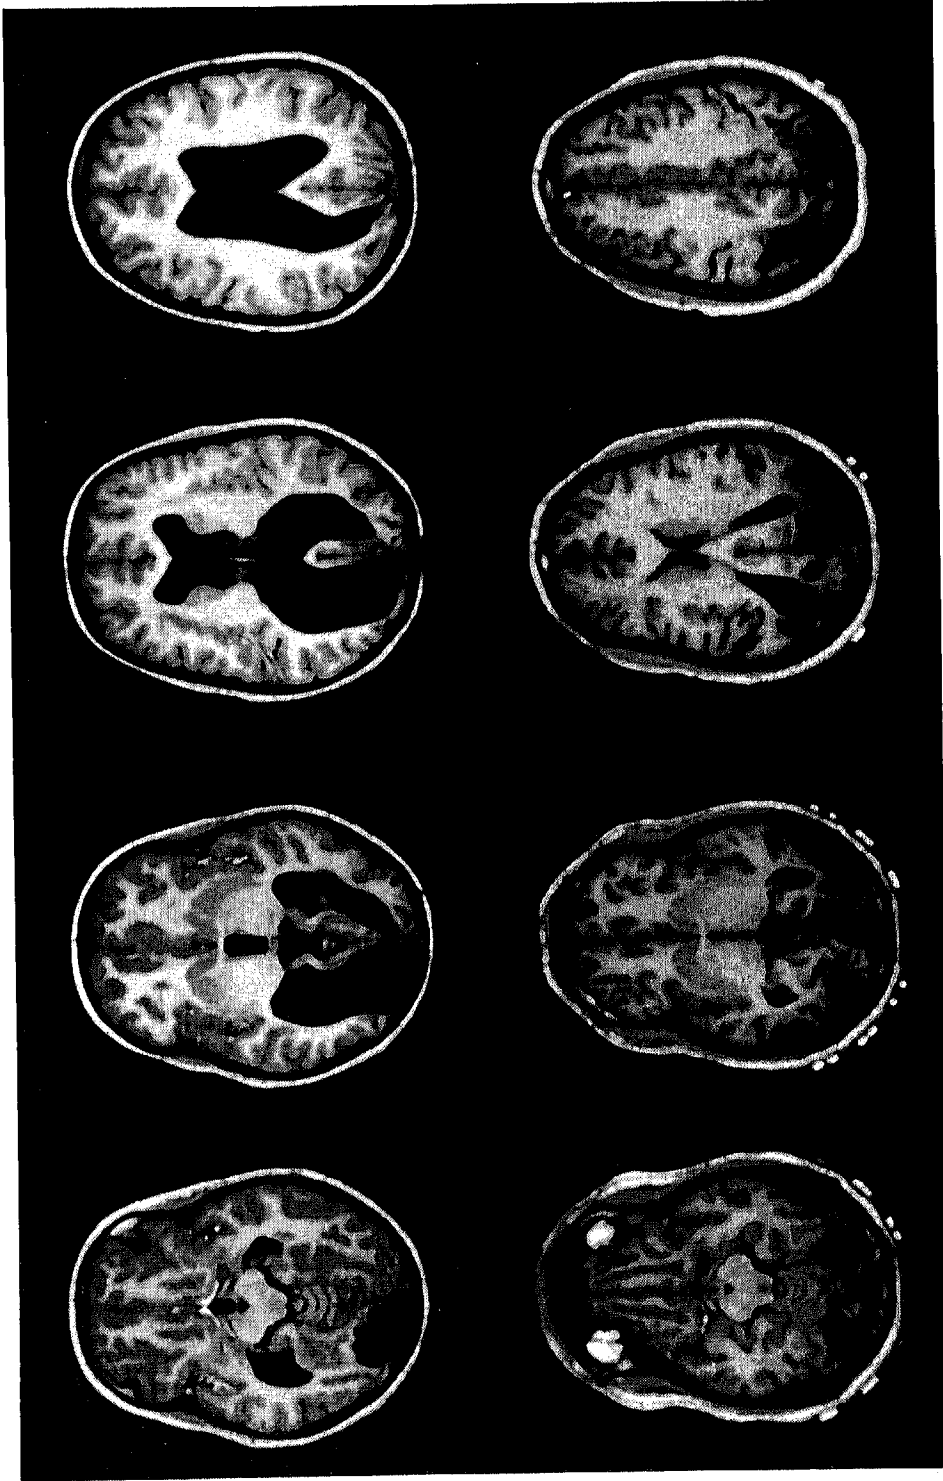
Top: Representative examples of the MRI sections of MS's brain (at 8:4 y). Bottom: Representative MRI sections through FJ's (at 19:2 y). The second upper and lower sections, from the left are matched sections through the AC-PC plane, the other sections are identically spaced above and below this plane. Left hemisphere is to the left in all sections.
